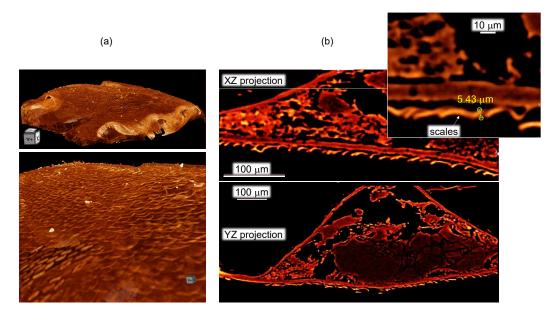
X-ray tomography of Peacock spider abdomen region. Large scale (a) and 3D tomography cross sections (b). Movies of the 3D sectioning XZ and YZ are added in Supplement.
